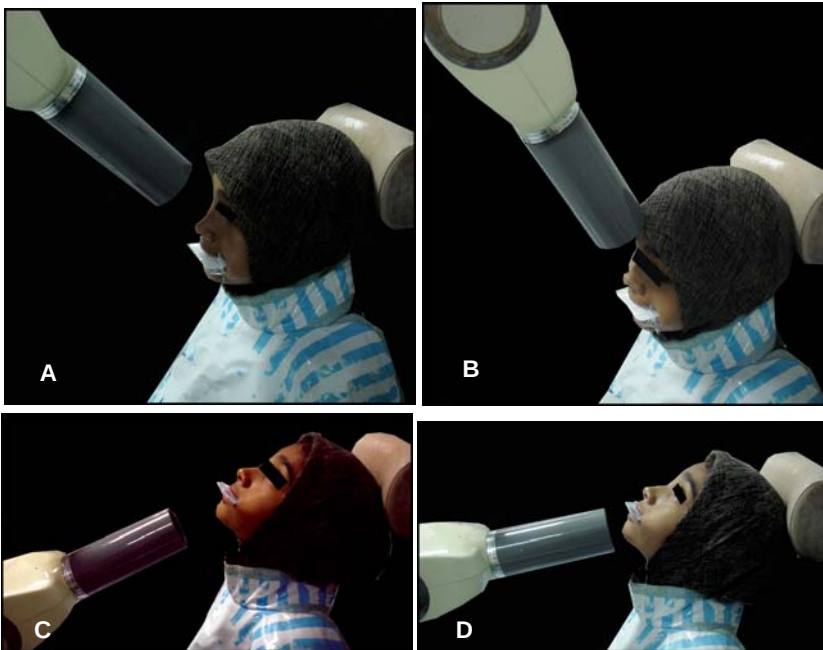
Obtaining an occlusal radiograph: A: Maxillary Anterior topographic radiograph; B: Maxillary Cross sectional radiograph; C: Mandibular cross sectional radiograph; D: Mandibular anterior topographic radiograph
